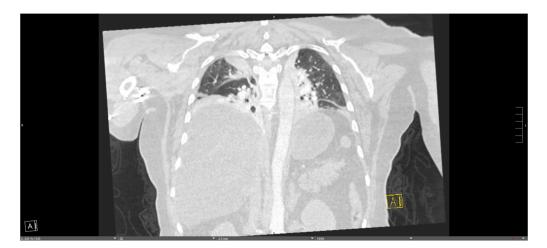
Computed tomography angiography on admission.
